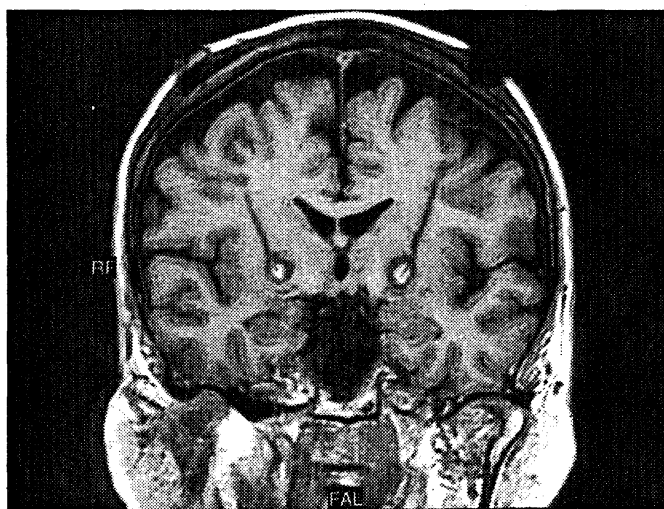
LM's post-operative magnetic resonance image showing bilateral pallidotomy lesions measuring 1 cm in diameter and possible small bilateral areas of associated haemorrhage and oedema extending into the posterior rim of the internal capsule.
